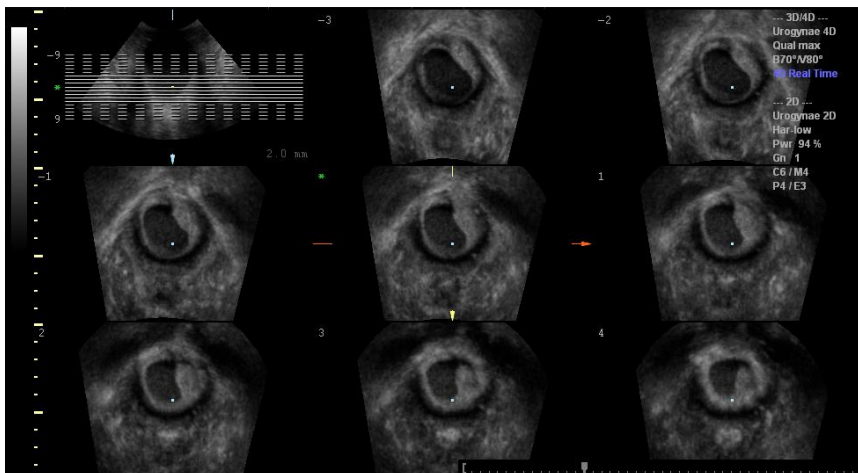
Tomographic ultrasound imaging of a urethral diverticulum.
